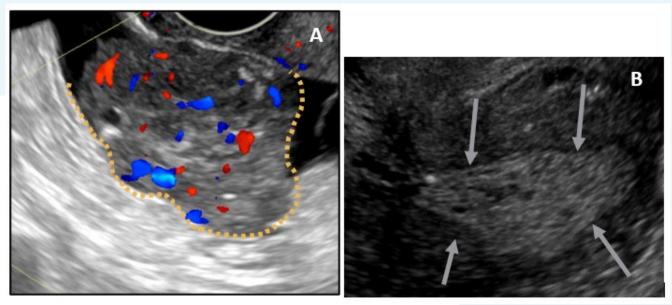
Ultrasound of left adnexa. A. Sagittal gray scale image left adnexa. B. Corresponding image of the endometrium in the same patient shows diffuse thickening and some cystic changes.
